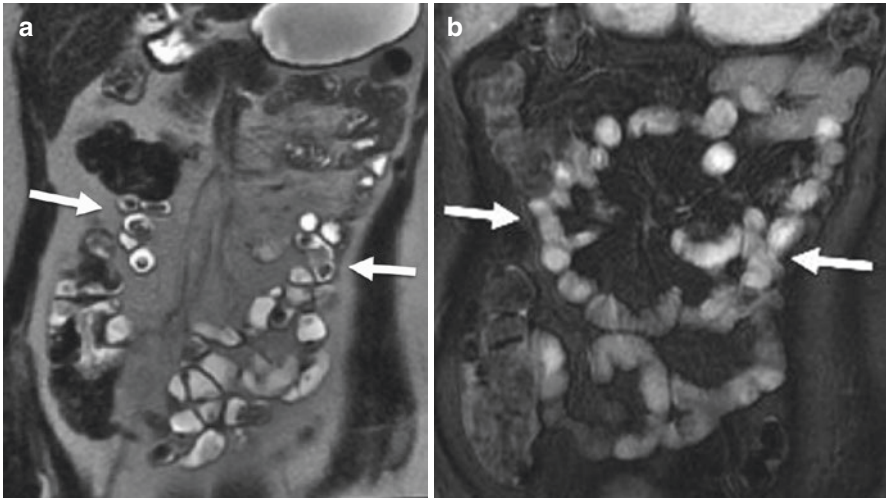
Coronal heavily T2-weighted image with an effective echo time of 180 ms (a) and corresponding coronal cine balanced steady-state free precession (BSSFP) image (b). In the T2-weighted image, the round filling defects in the small bowel lumen (arrows in a) are flow void artifacts created by peristalsis. This is confirmed by correlating with the BSSFP series which has a faster acquisition time and does not show these filling defects (arrows in b)
